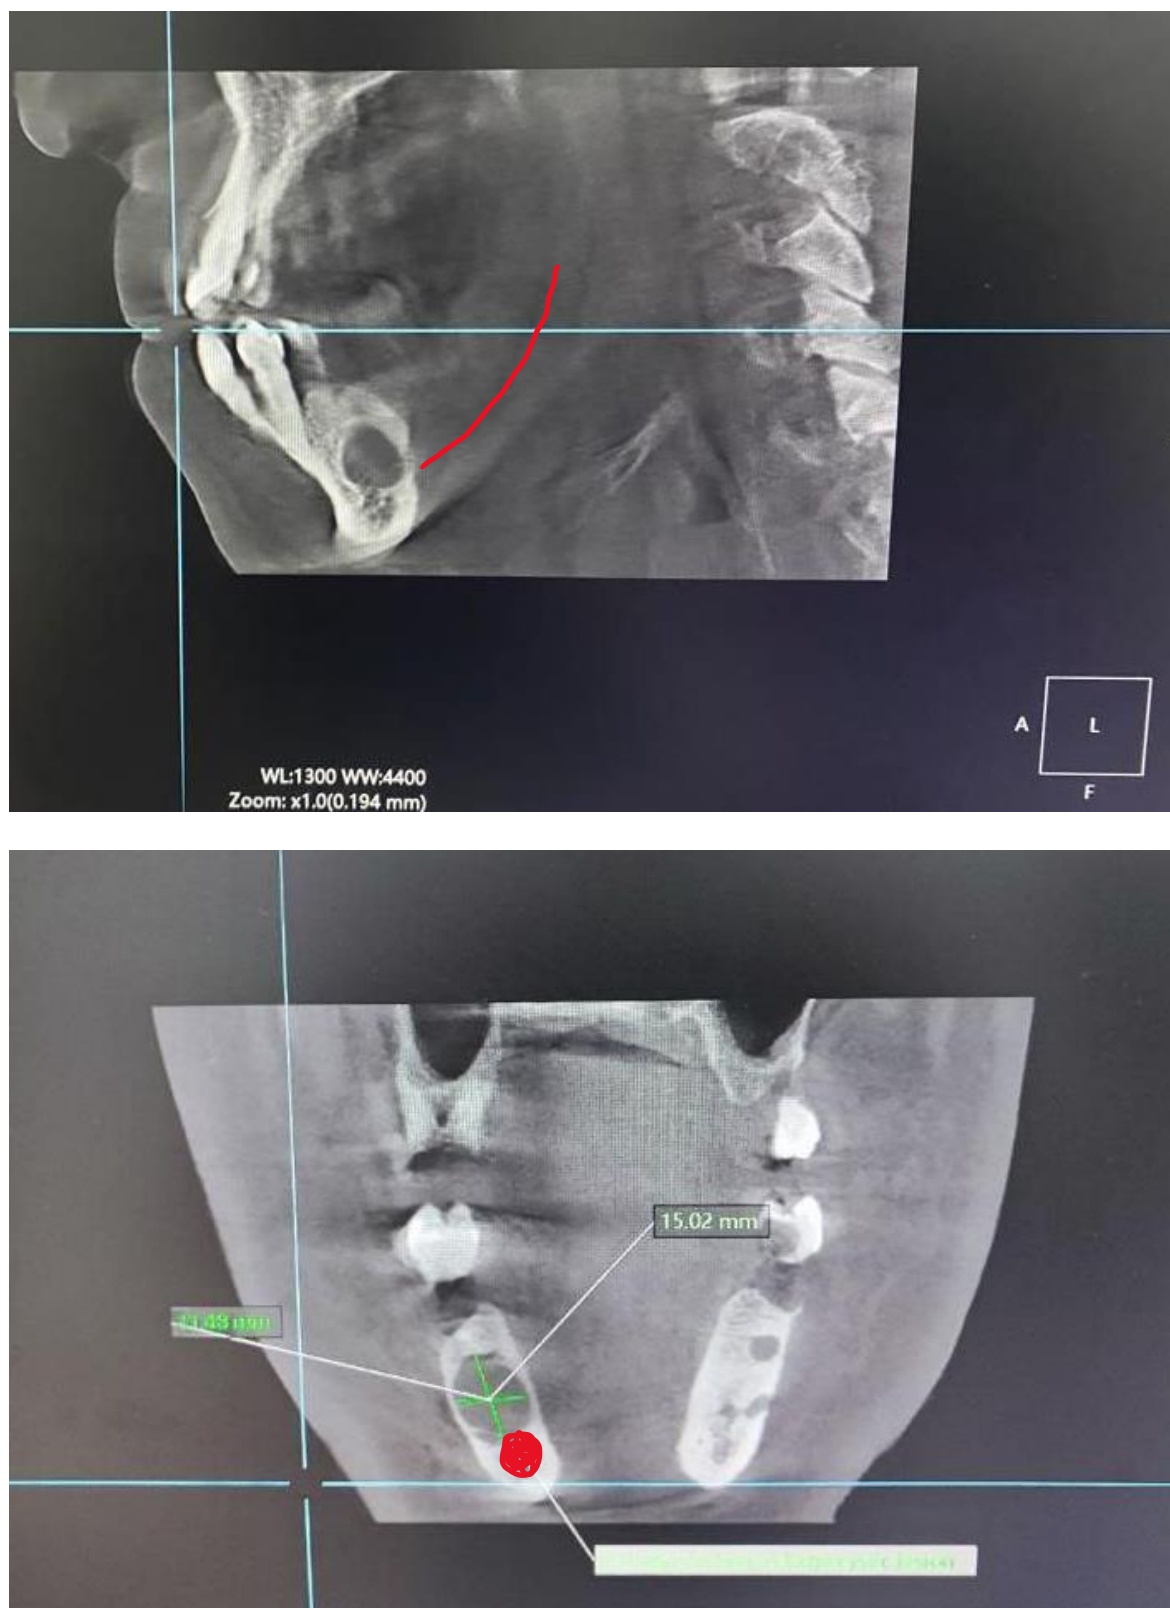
Three-dimensional sagittal view of CBCT image shows a small periapical pathology of the mandibular second left molar. 3b) Three dimensional coronal view of CBCT shows a small periapical pathology of the mandibular second molar.
